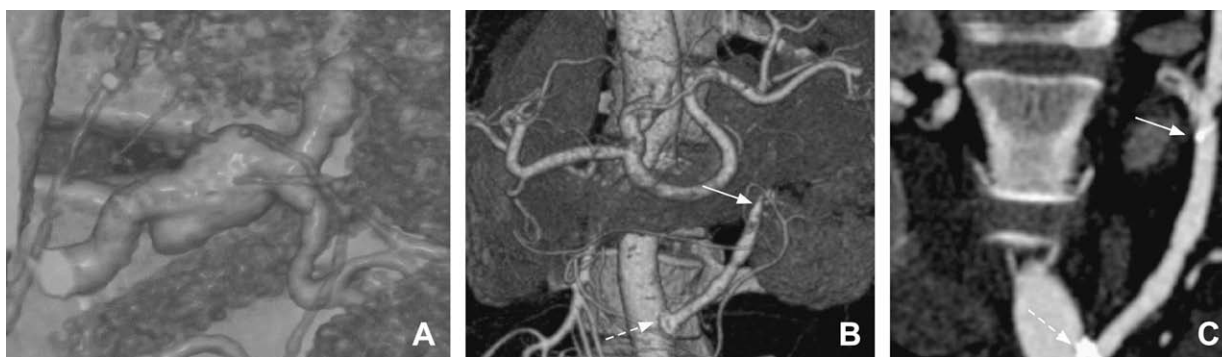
A: Three-dimensional reconstruction (volume rendering technique) of the distal left renal artery aneurysm (angio-CT scan). B: Three-dimensional reconstruction (volume rendering technique) of the vein bypass at discharge (angio-CT scan). C: Control-MRI (maximal intensity projection technique) after PTA. The dotted arrows point to the proximal anastomosis (PAS-Port™ implant), the full arrows point to the distal anastomosis (13 individual microclips).
